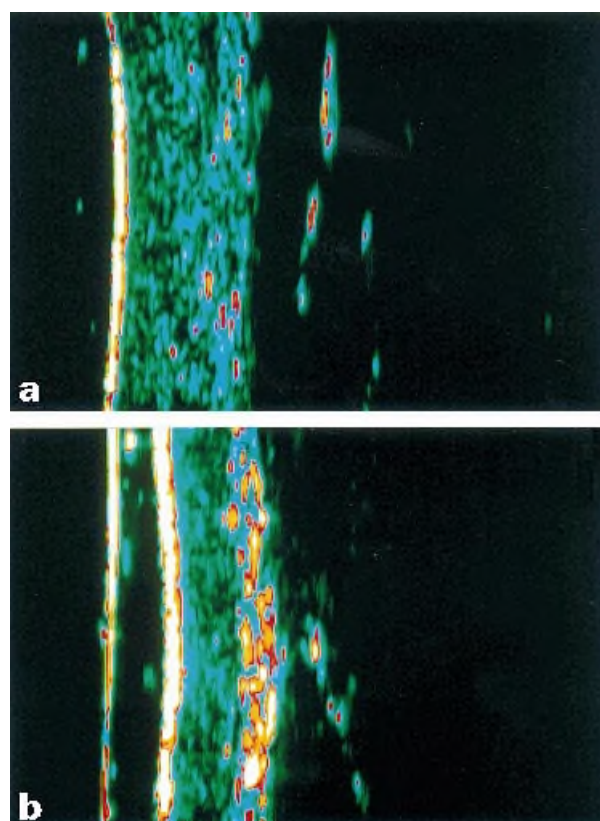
(a) Ultrasound (20 MHz) of the skin of a pregnant woman (group IV) 2 weeks before delivery. At the lower leg lateral distal, the skin thickness was 1.75 mm and the echodensity was 15. (b) Ultrasound (20 MHz) of the skin of the same subject 6 weeks after delivery. In comparison with (a) at the same measuring point, the skin thickness decreased (1.35 mm) and the echodensity increased (26).
